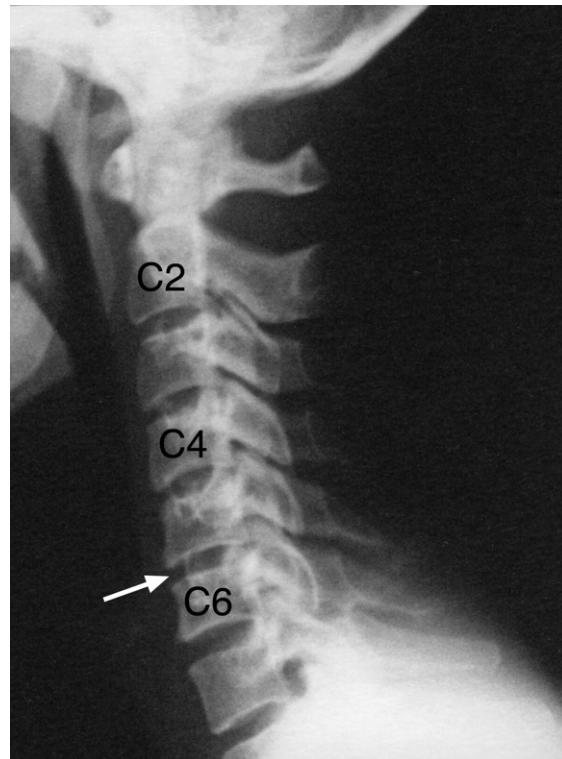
Cervical spine lateral plain X-ray image. Note (i) there is a loss of the normal lordosis of the cervical spine with some straightening of the spine from C3 to C6, and (ii) some thinning of the C5–6 intervertebral disc space height (arrow).
